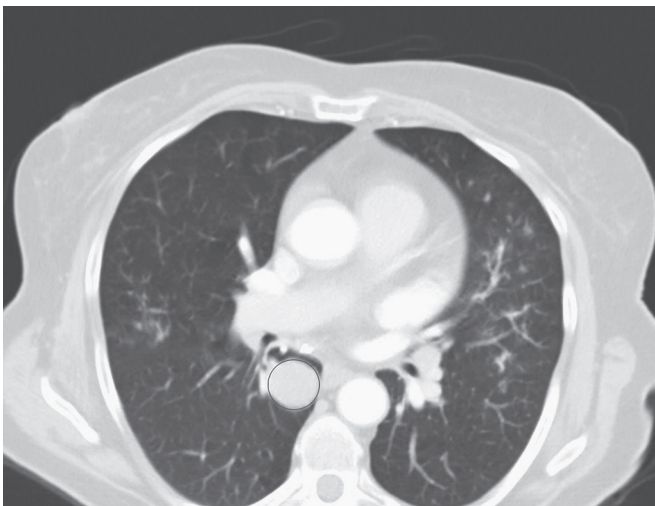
■ Chest CT scan of a typical carcinoid.
